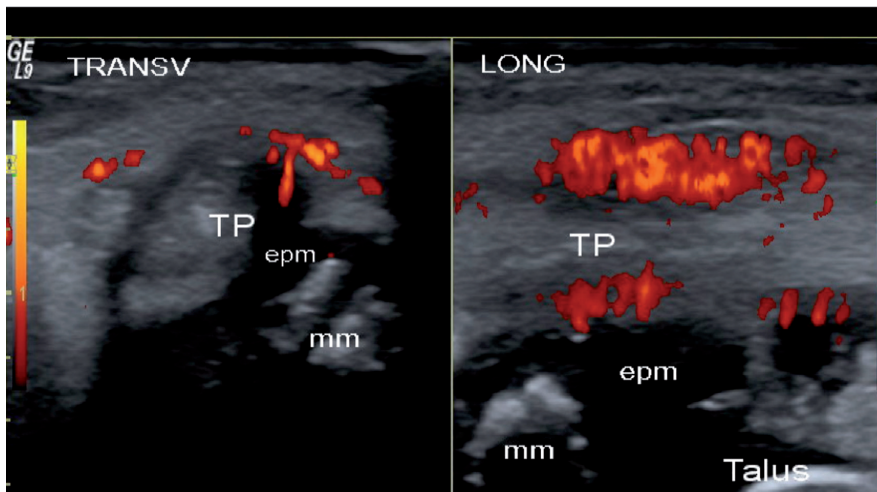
Juvenile idiopathic arthritis. Longitudinal (left image) and transverse (right image) scans of the ankle joint at the level of the medial malleolus (mm) shows tenosynovitis of tibialis posterior (TP) in a 9-year-old child. Synovial vascularisation detected in the tendon sheath by power Doppler reflects disease activity. The epiphyseal cartilage of malleolus (epm) is visible in both transverse and longitudinal scans as an anechoic structure. Dynamic examination allows distinguishing the epiphyseal cartilage of malleolus from effusion/synovitis.
